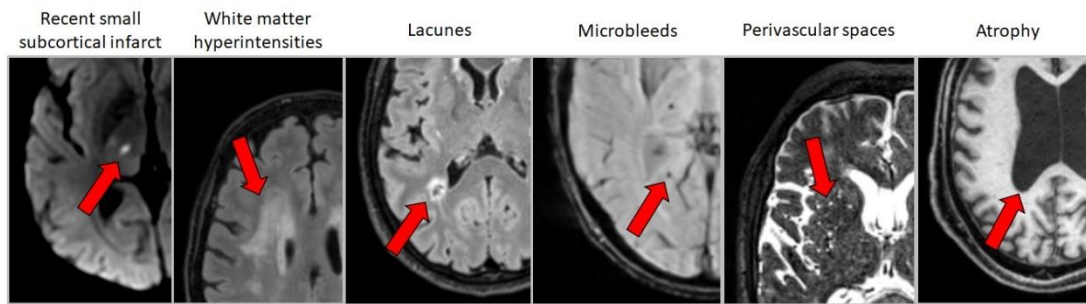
SVD lesions observed on brain MRI. The images came from SVD patients from the Mild Stroke Study 3 (see Chapter 5).
